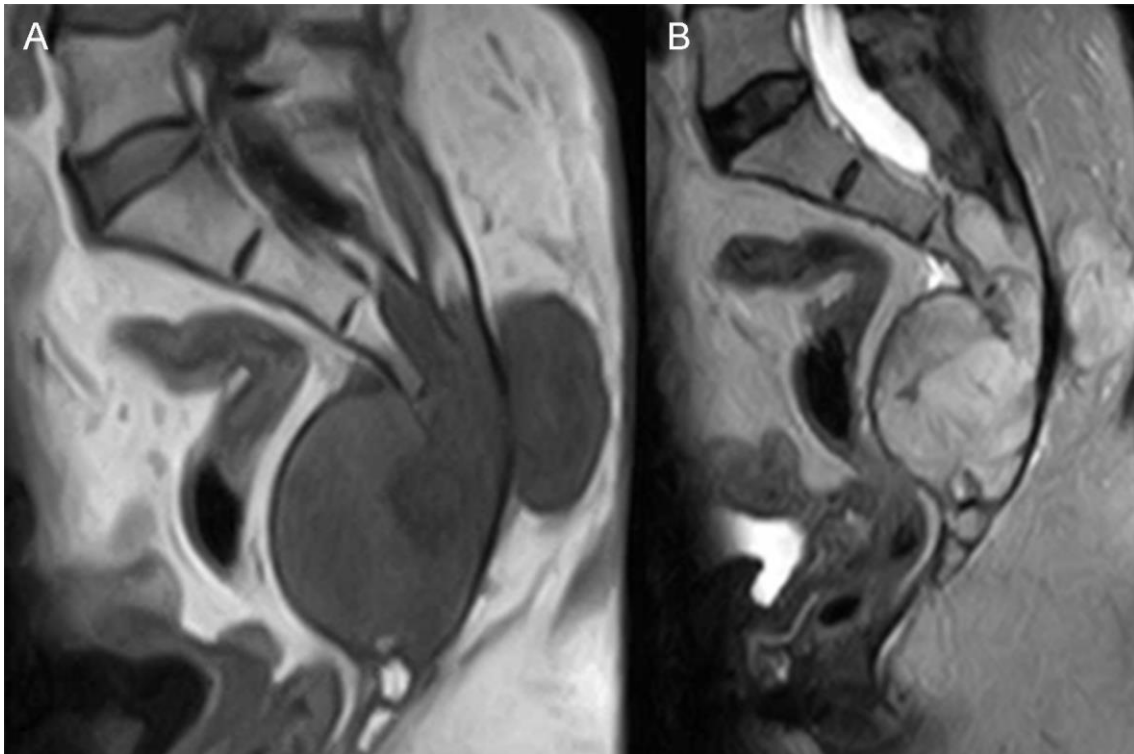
Sacral chordoma, sagittal MRI images A. T1, B. T2 sequence*
